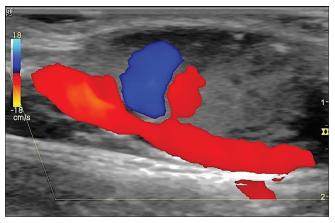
Color Doppler exhibited slow internal flow with Ying-Yang sign
